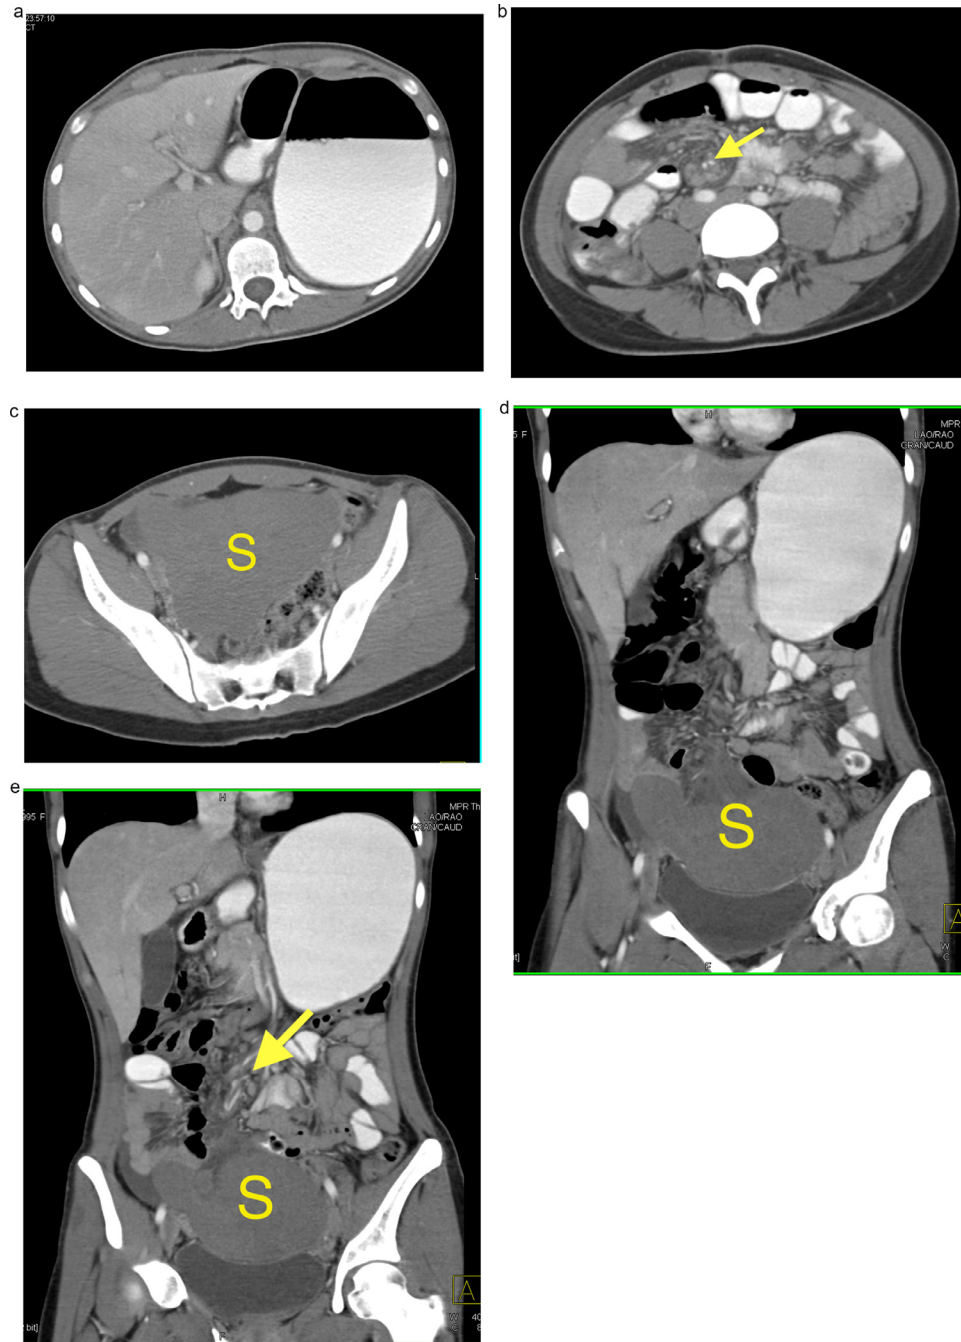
(A-E) A 16-year-old female presented to her local hospital with severe periumbilical abdominal pain and a CT was done to better define the cause of the patient's symptoms. The CT scan demonstrated a torsed spleen situated in the pelvis with swirling of the mesenteric vessels leading to infarction of the wandering spleen. (A) CT scan through the upper abdomen shows a normal liver and a distended stomach with no evidence of the spleen. (B) CT scans through the mid-abdomen demonstrate the swirling of the mesenteric vessels (arrow) consistent with low flow to the spleen. (C) CT scans through the pelvis demonstrate a low-density mass in the pelvis (S) which was an infarcted ectopic spleen. (D, E) CT scans in coronal plane nicely define the infarcted wandering spleen in the pelvis (S) with haziness by splenic hilum due to twisting of the mesenteric arcade (arrow).
